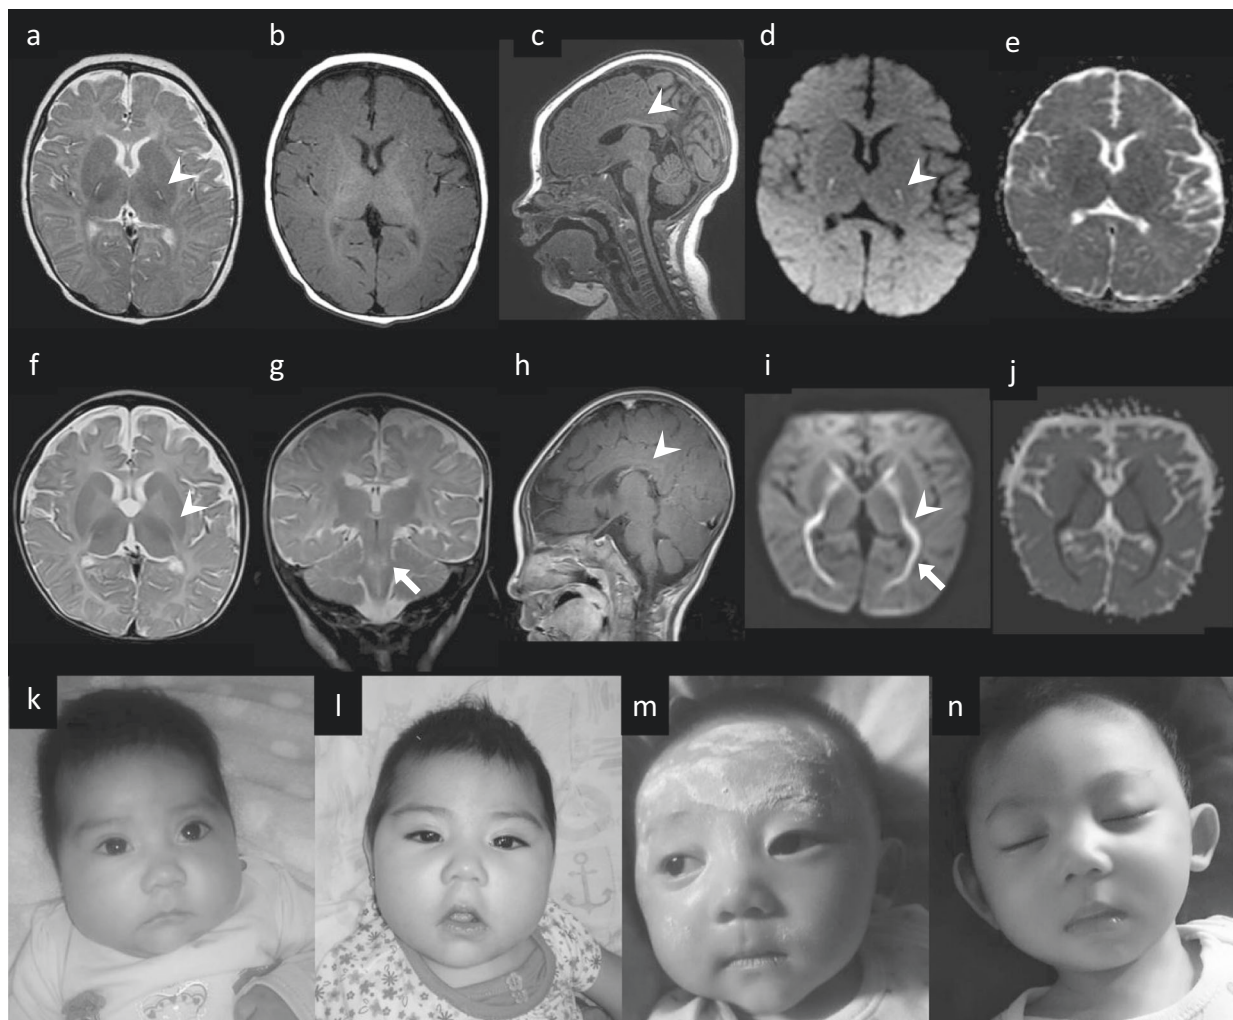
Brain MRI and facial photographs of patients. Brain MRI in patient 1 (a–e) and patient 2 (f–j) at the age of 5 months. T2-weighted images (a, f, g); T1-weighted images (b, c, h); diffusion-weighted images (DWI) (d, i); ADC images (e, j) were shown. T2-weighted images and DWI in both patients show hyperintensity of pyramidal tracts in the internal capsule, delayed myelination, and thin corpus callosum (white arrowhead), corresponding to low signal on the ADC
